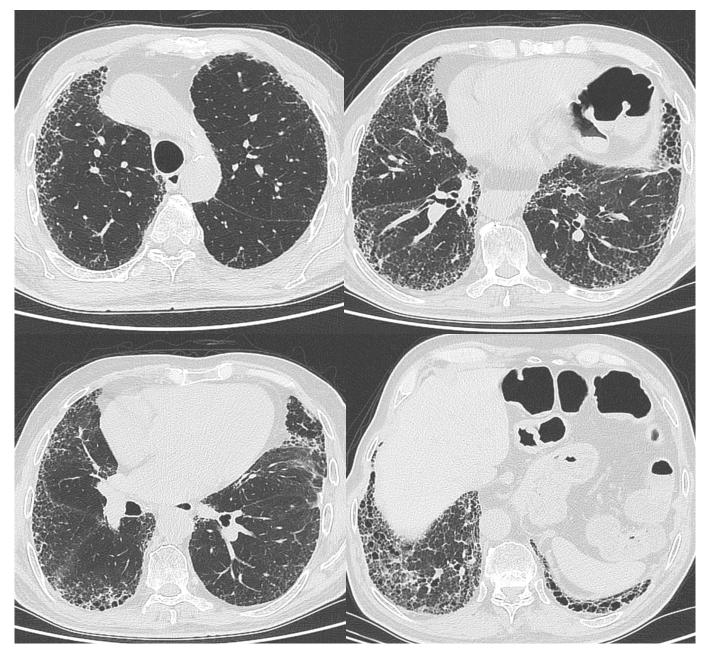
Usual interstitial pneumonia (UIP) pattern at High-resolution computed tomography (HRCT)
